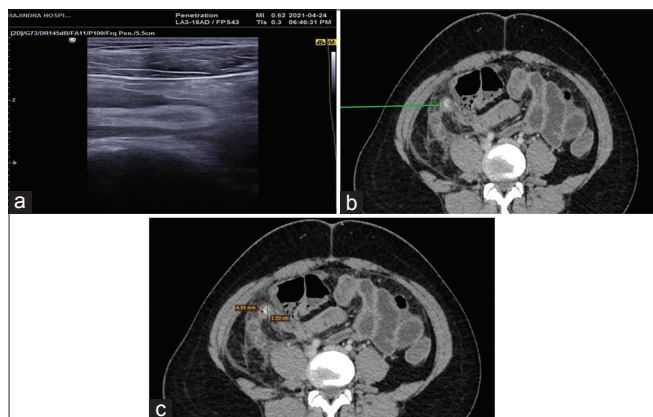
(a) Ultrasound, (b) CECT abdomen axial section, (c) CECT abdomen axial section
